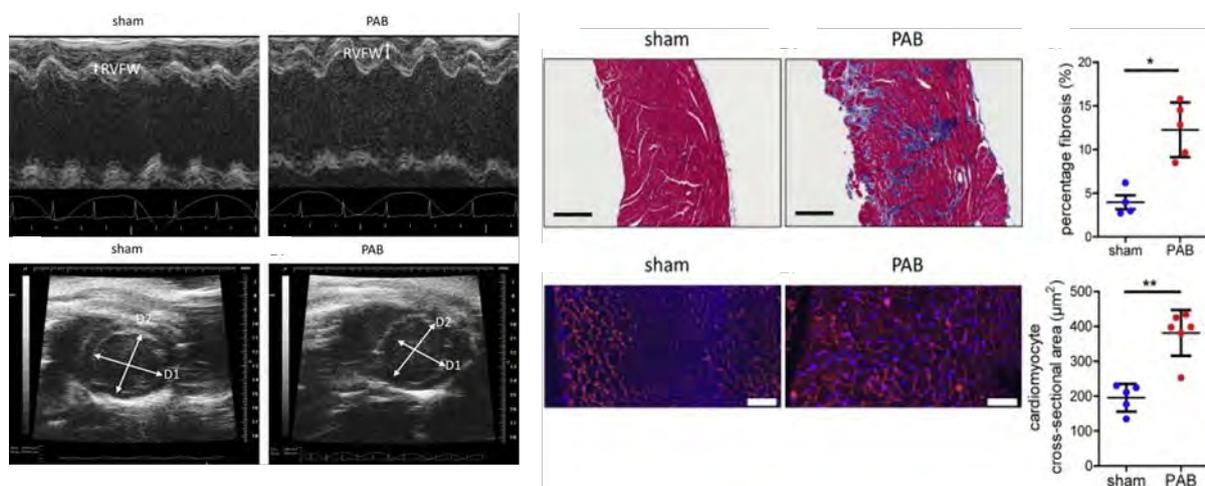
Pathologic changes in the heart induced by chronic pressure overload. Left panels echocardiographic characterisation; middle and right panels, image analysis to quantify fibrosis and cardiomyocyte hypertrophy. Egemnazarov B. et al., J Am Soc Echocardiogr. 2015 Jul;28(7):828-43.
